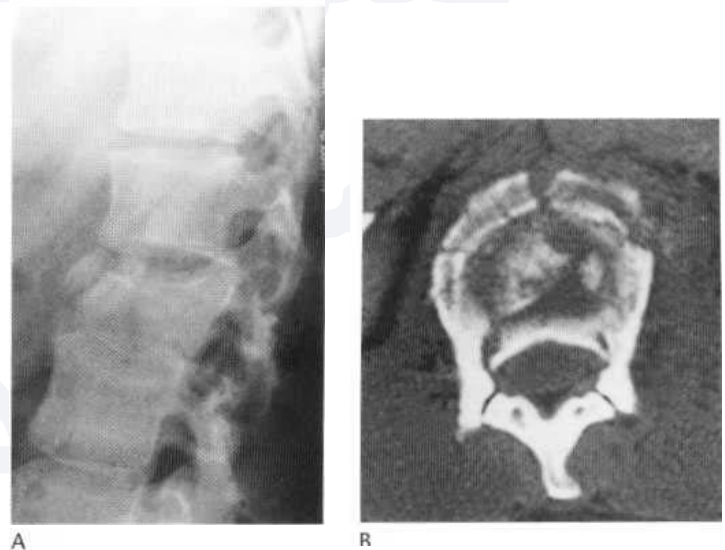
Compression fracture of L2. (A) Plain lateral radiograph indicates wedging of L2, with posterior bulging of the dorsal margin. (B) CT scan demonstrates the extent of the impingement of the dorsal fragment upon the spinal canal.
